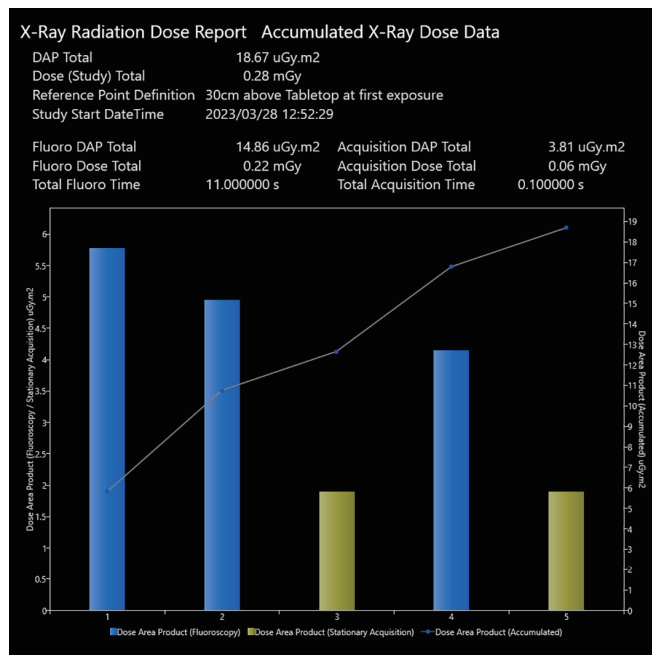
X-ray exposure dose report
